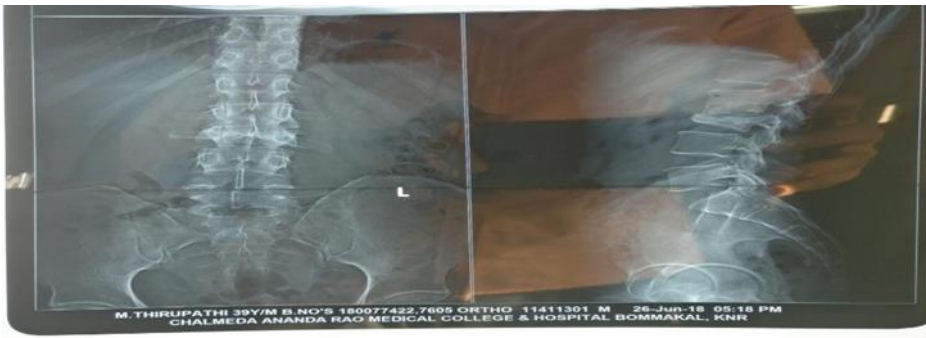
Pre-operative radiographs showing tuberculosis at L2-L3 level
